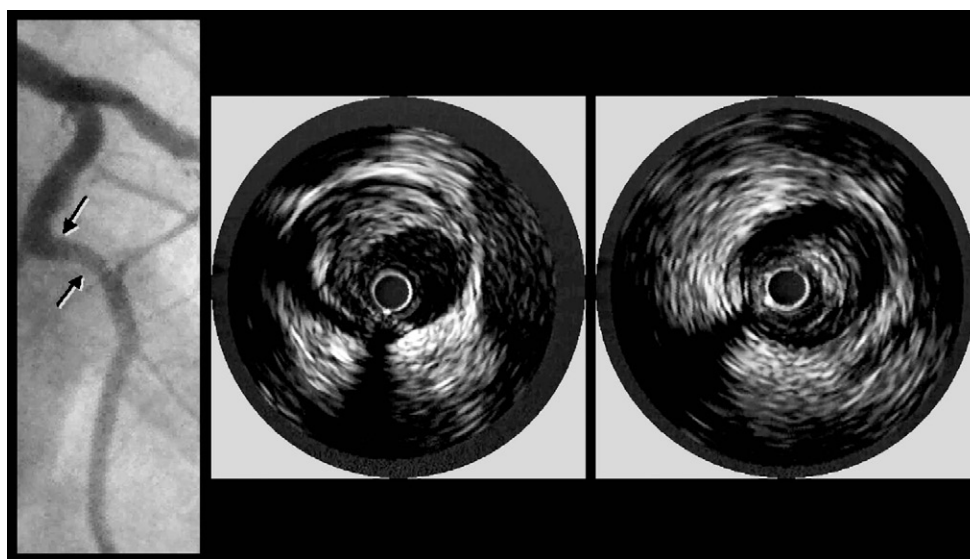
Angiographic (left panel) underestimation of the severity of coronary artery disease, revealed by intravascular ultrasound (center and right panels). There is mild angiographic luminal narrowing (distal arrow) when the lesion is compared with a pseudonormal reference segment (proximal arrow). On intravascular ultrasound, the reference segment shows significant plaque burden (center panel), and the severity of the target lesion (right panel) is better appreciated.
